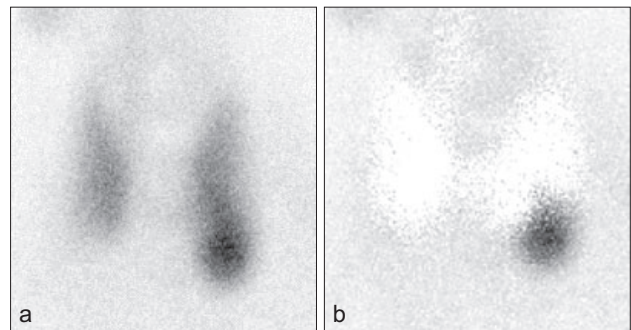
a, b. Scintigraphy: Focal uptake of TF in favour of left inferior parathyroid adenoma: ^{99m}Tc -tetrofosmin scintigraphy (a) and thyroid subtraction image (b).
